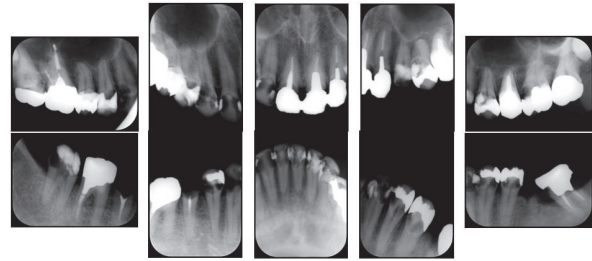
Dental X-ray photographs of the patient 1 at first general anesthesia, showing dental caries in most teeth.
